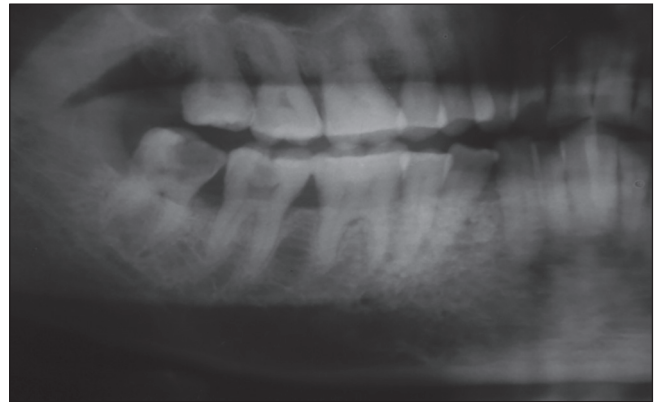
Radiography showing the extent of the lesion
